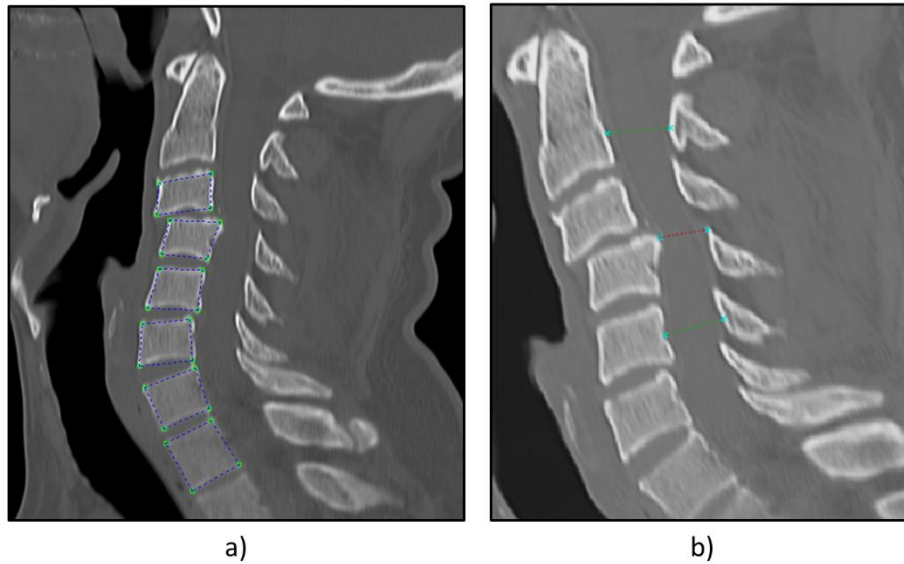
Mid-sagittal CT images with anatomical landmarks identified: (a) corners of C3-T1 vertebral bodies; (b) canal space at the level of injury, and the superior and inferior uninjured levels.
